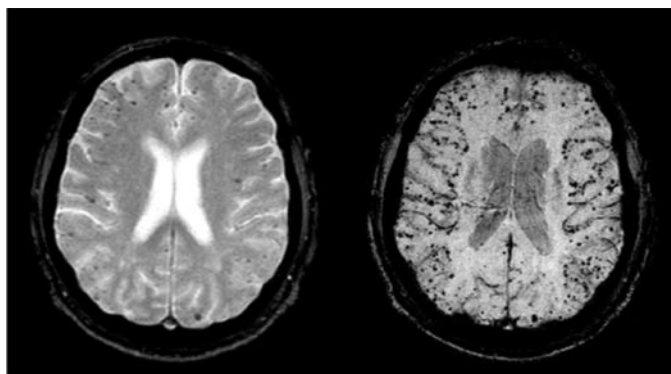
Micro bleeds in magnetic resonance image.
